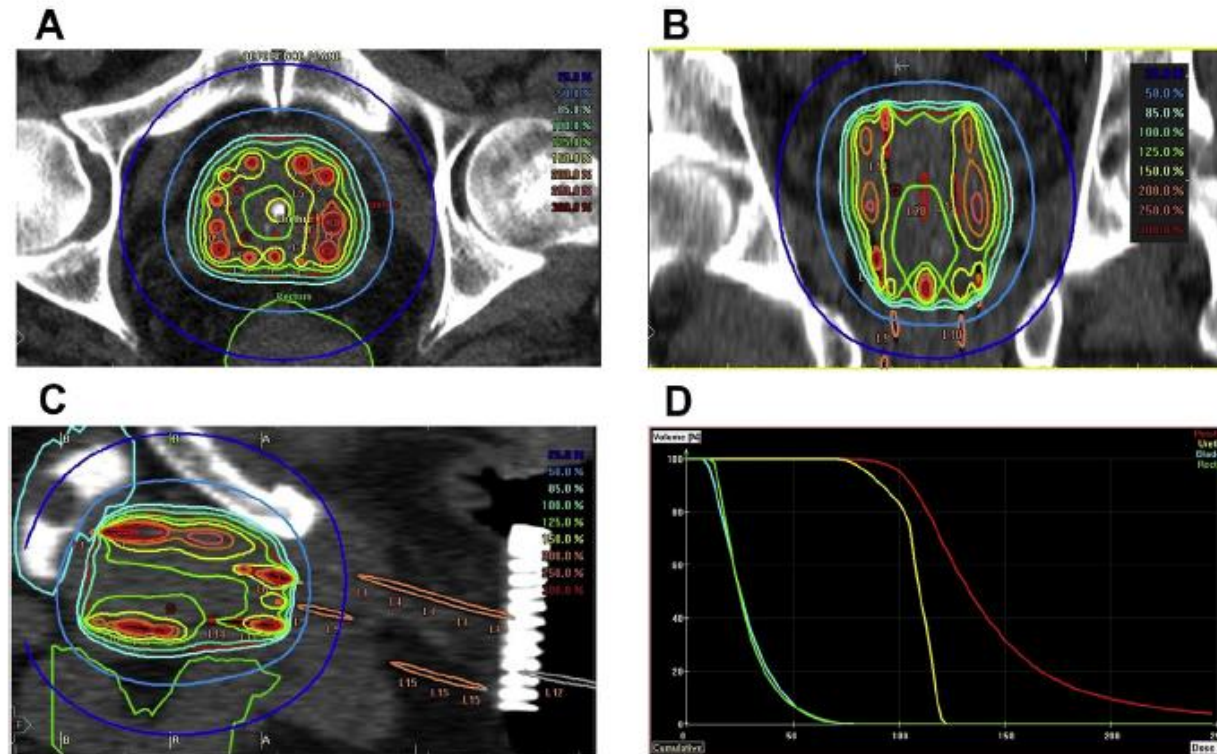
Results of inverse optimisation with Oncentra Prostate (Elekta-Brachytherapy, Elekta AB, Sweden) using hybrid inverse planning optimisation for a computed tomography-based treatment plan of high dose rate prostate brachytherapy. The isodose lines overlay to (a) the central axial plane (reference plane), (b) a coronal plane and (c) a representative sagittal plane. (d) shows the corresponding dose volume histogram curves for the planning target volume, urethra and rectum. One hundred per cent corresponds to the aimed dose prescription.
